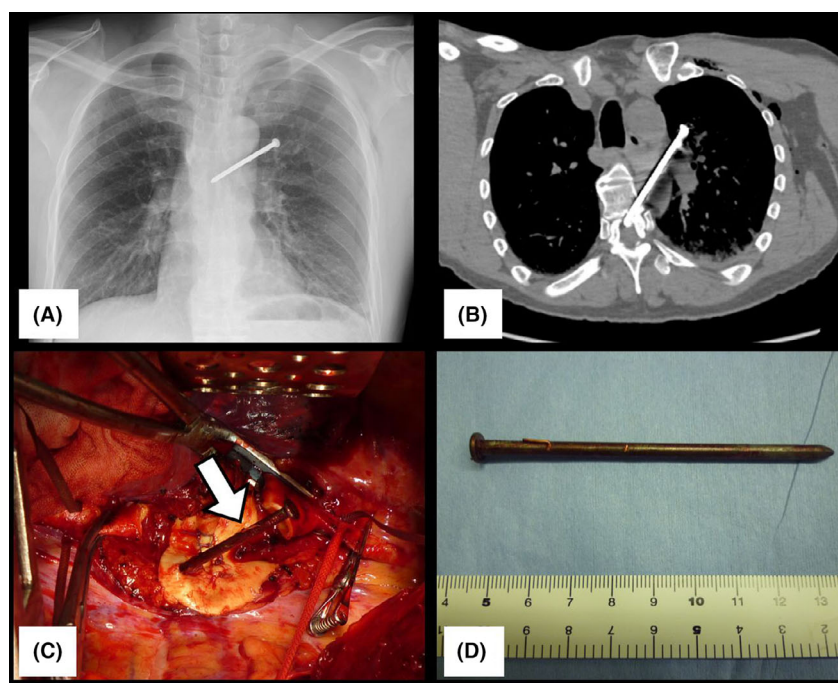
Imaging of a 44-year-old man with an accidental nail-gun injury to the chest. A, Chest radiograph demonstrates a nail in the mediastinum. B, Multidetector computed tomography demonstrating a nail penetrating the thoracic aorta. C, Intraoperative view depicts the nail (arrow) just before its removal. D, The removed nail, with a diameter of approximately 2 mm and a length of approximately 9 cm.
